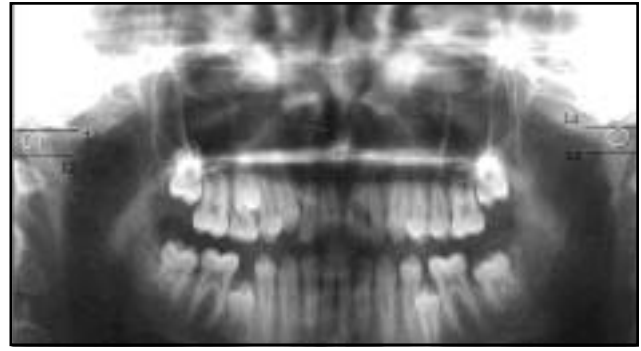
The view of ROIs on left and right condyles on a panoramic radiograph. ROI - region of interest
